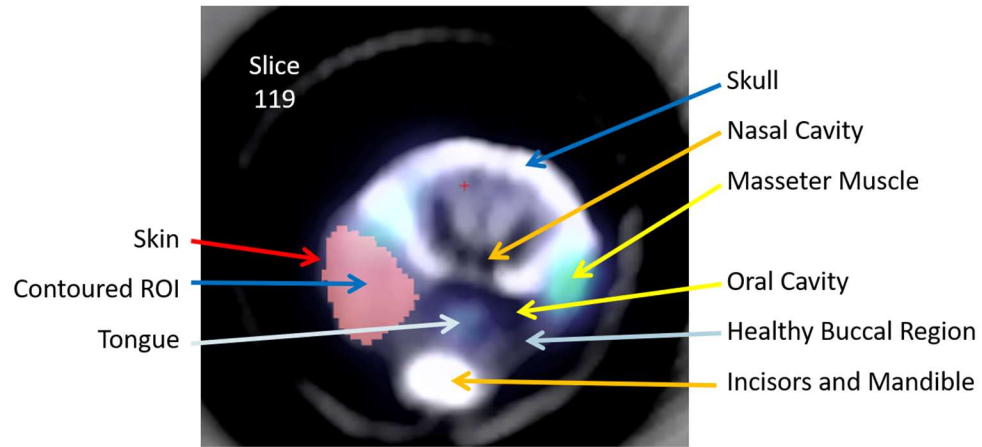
Example PET/CT slice with anatomy labeled.
